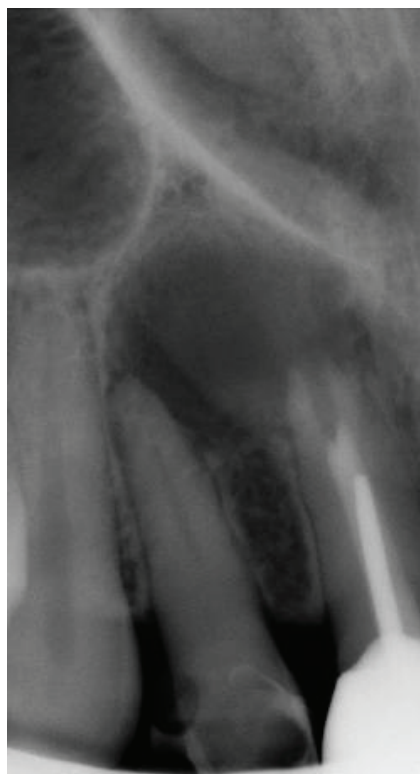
X-ray picture of radicular cyst in tuberculosis periodontitis
